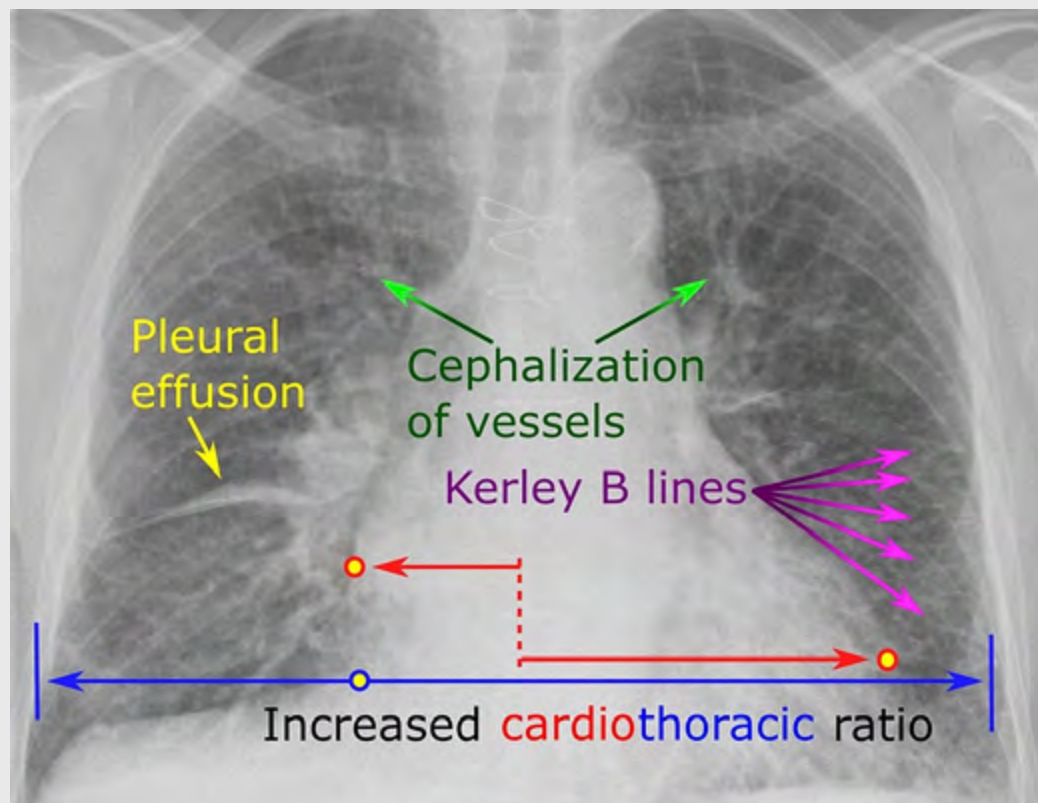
Chest x-ray features of congestive heart failure
